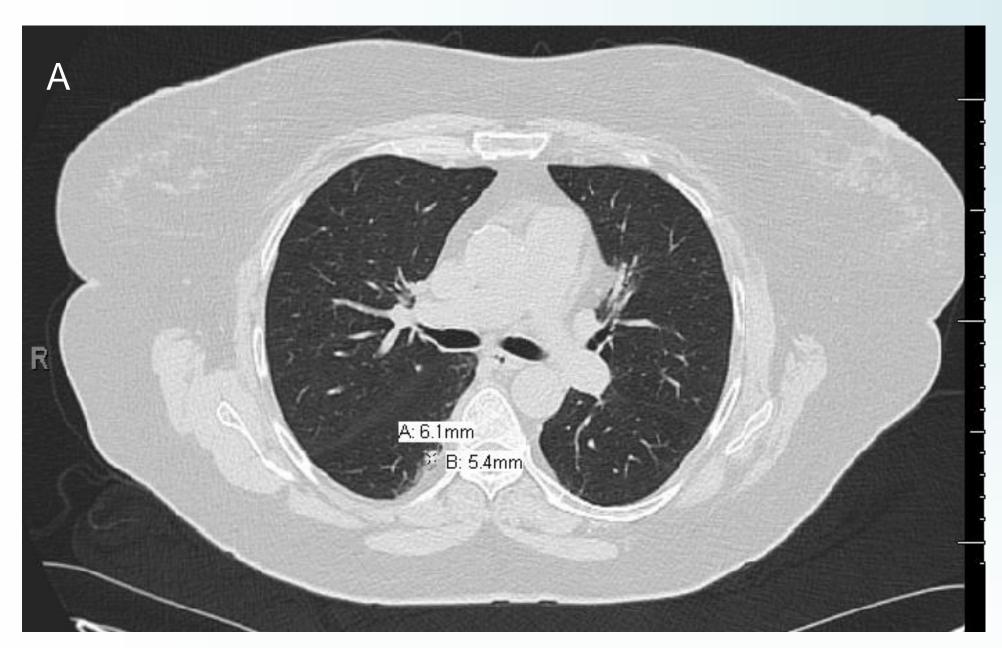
CT shows multiple small, bilateral pulmonary nodules, the largest measuring 6 mm.
